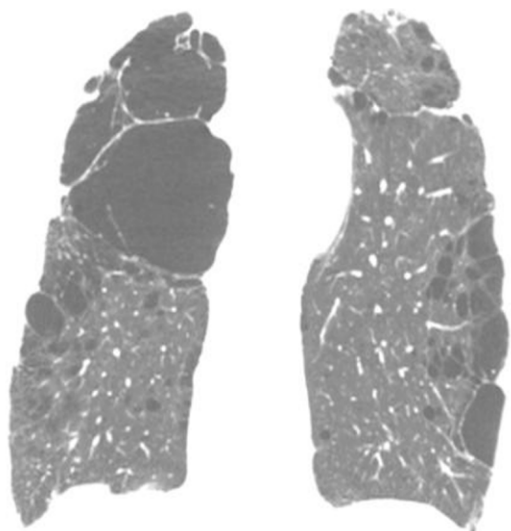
Coronal CT scans with lung window settings of a patient with centrilobular and paraseptal emphysema who has multiple bullae, the largest of which are located in the right lung apex.
